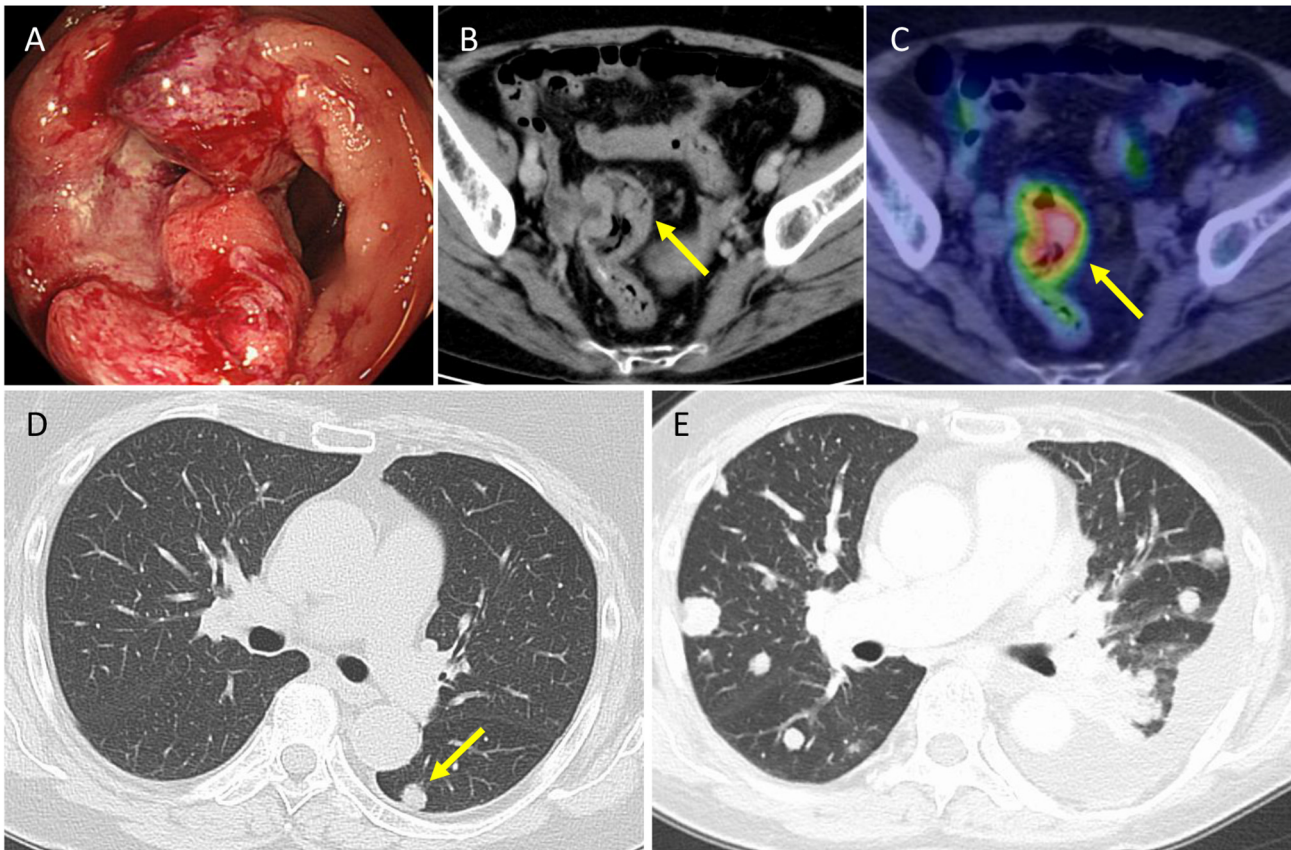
Imaging during the rectal cancer diagnosis and metastatic recurrence. A) Colonoscopic image showing circumferential wall thickening of the rectum. B) Contrast-enhanced computed tomography (CT) image showing wall thickening of the rectum (arrow). C) Fluorodeoxyglucose-positron emission tomography (FDG-PET) image showing increased FDG uptake in the rectum (arrow). D) CT image two years after surgery showing a metastatic tumor in lung segment 6 of the left lung (arrow). E) CT image eight years after surgery showing multiple metastatic tumors in both lungs and metastasis to the mediastinal lymph nodes.
